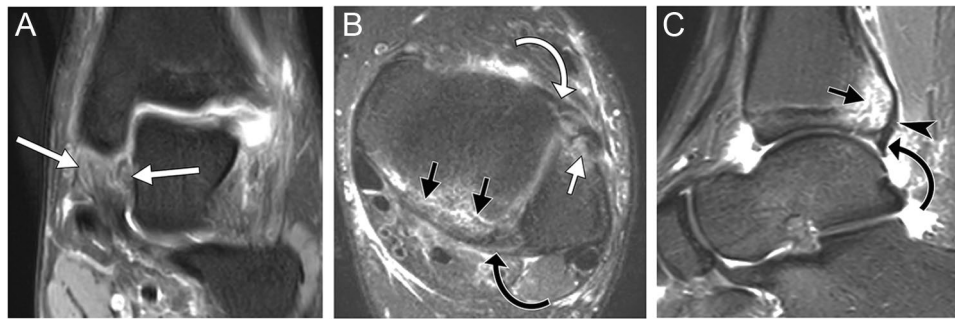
Stage II Lauge-Hansen pronation-abduction injury in a 23-year-old male soccer player. Coronal fat-suppressed proton-density-weighted (A), axial T2-weighted (B), and sagittal STIR (C) MR images of the ankle demonstrate tear of the deep and superficial deltoid ligament (white arrows, A), avulsion fracture of the distal fibula (straight white arrow, B) at the attachment of the anterior tibiofibular
